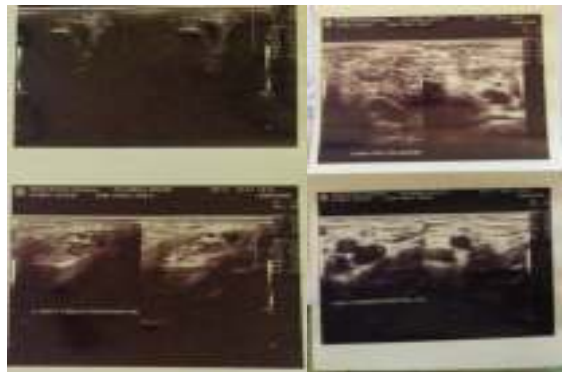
Doppler ultrasound showing left pedis soft tissue swelling with peripheral arteritis in the cutaneous lesion area
